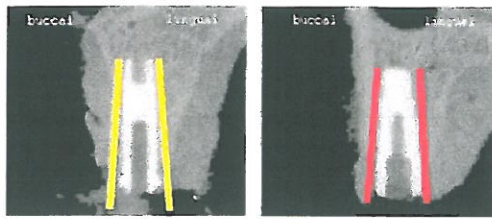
Cross-sectional image of implant sites 10 and 12 derived from a volumetric CT scan. The *lines* designate the vertical line integral used to collect bone density values on the buccal and lingual sides. Bresenham's line algorithm was implemented for collecting the bone density information along a discretized line
